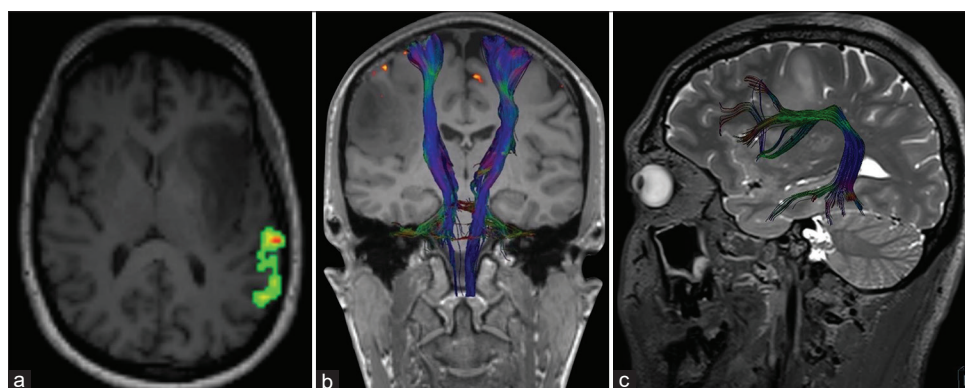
(a) Functional magnetic resonance imaging in a patient with insular glioma. Hemodynamic correlates related to a syntax paradigm (Gutbrod *et al.*, 2012^[44]) in the Wernicke area, left hemisphere. (b) Fiber tracking of the corticospinal tract in a patient with LGG. There is a distortion, but no infiltration of the right corticospinal tract. (c) Fiber tracking: Distorted arcuate fascicle in patients with oligodendroglioma
